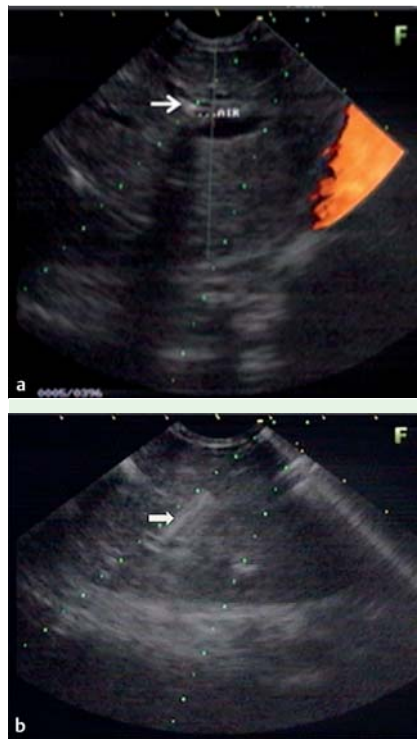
Endoscopic ultrasound (EUS) views showing: a minimal dilatation of a peripheral bile duct (arrow); b the peripheral bile duct being punctured by an EUS needle (arrow).
